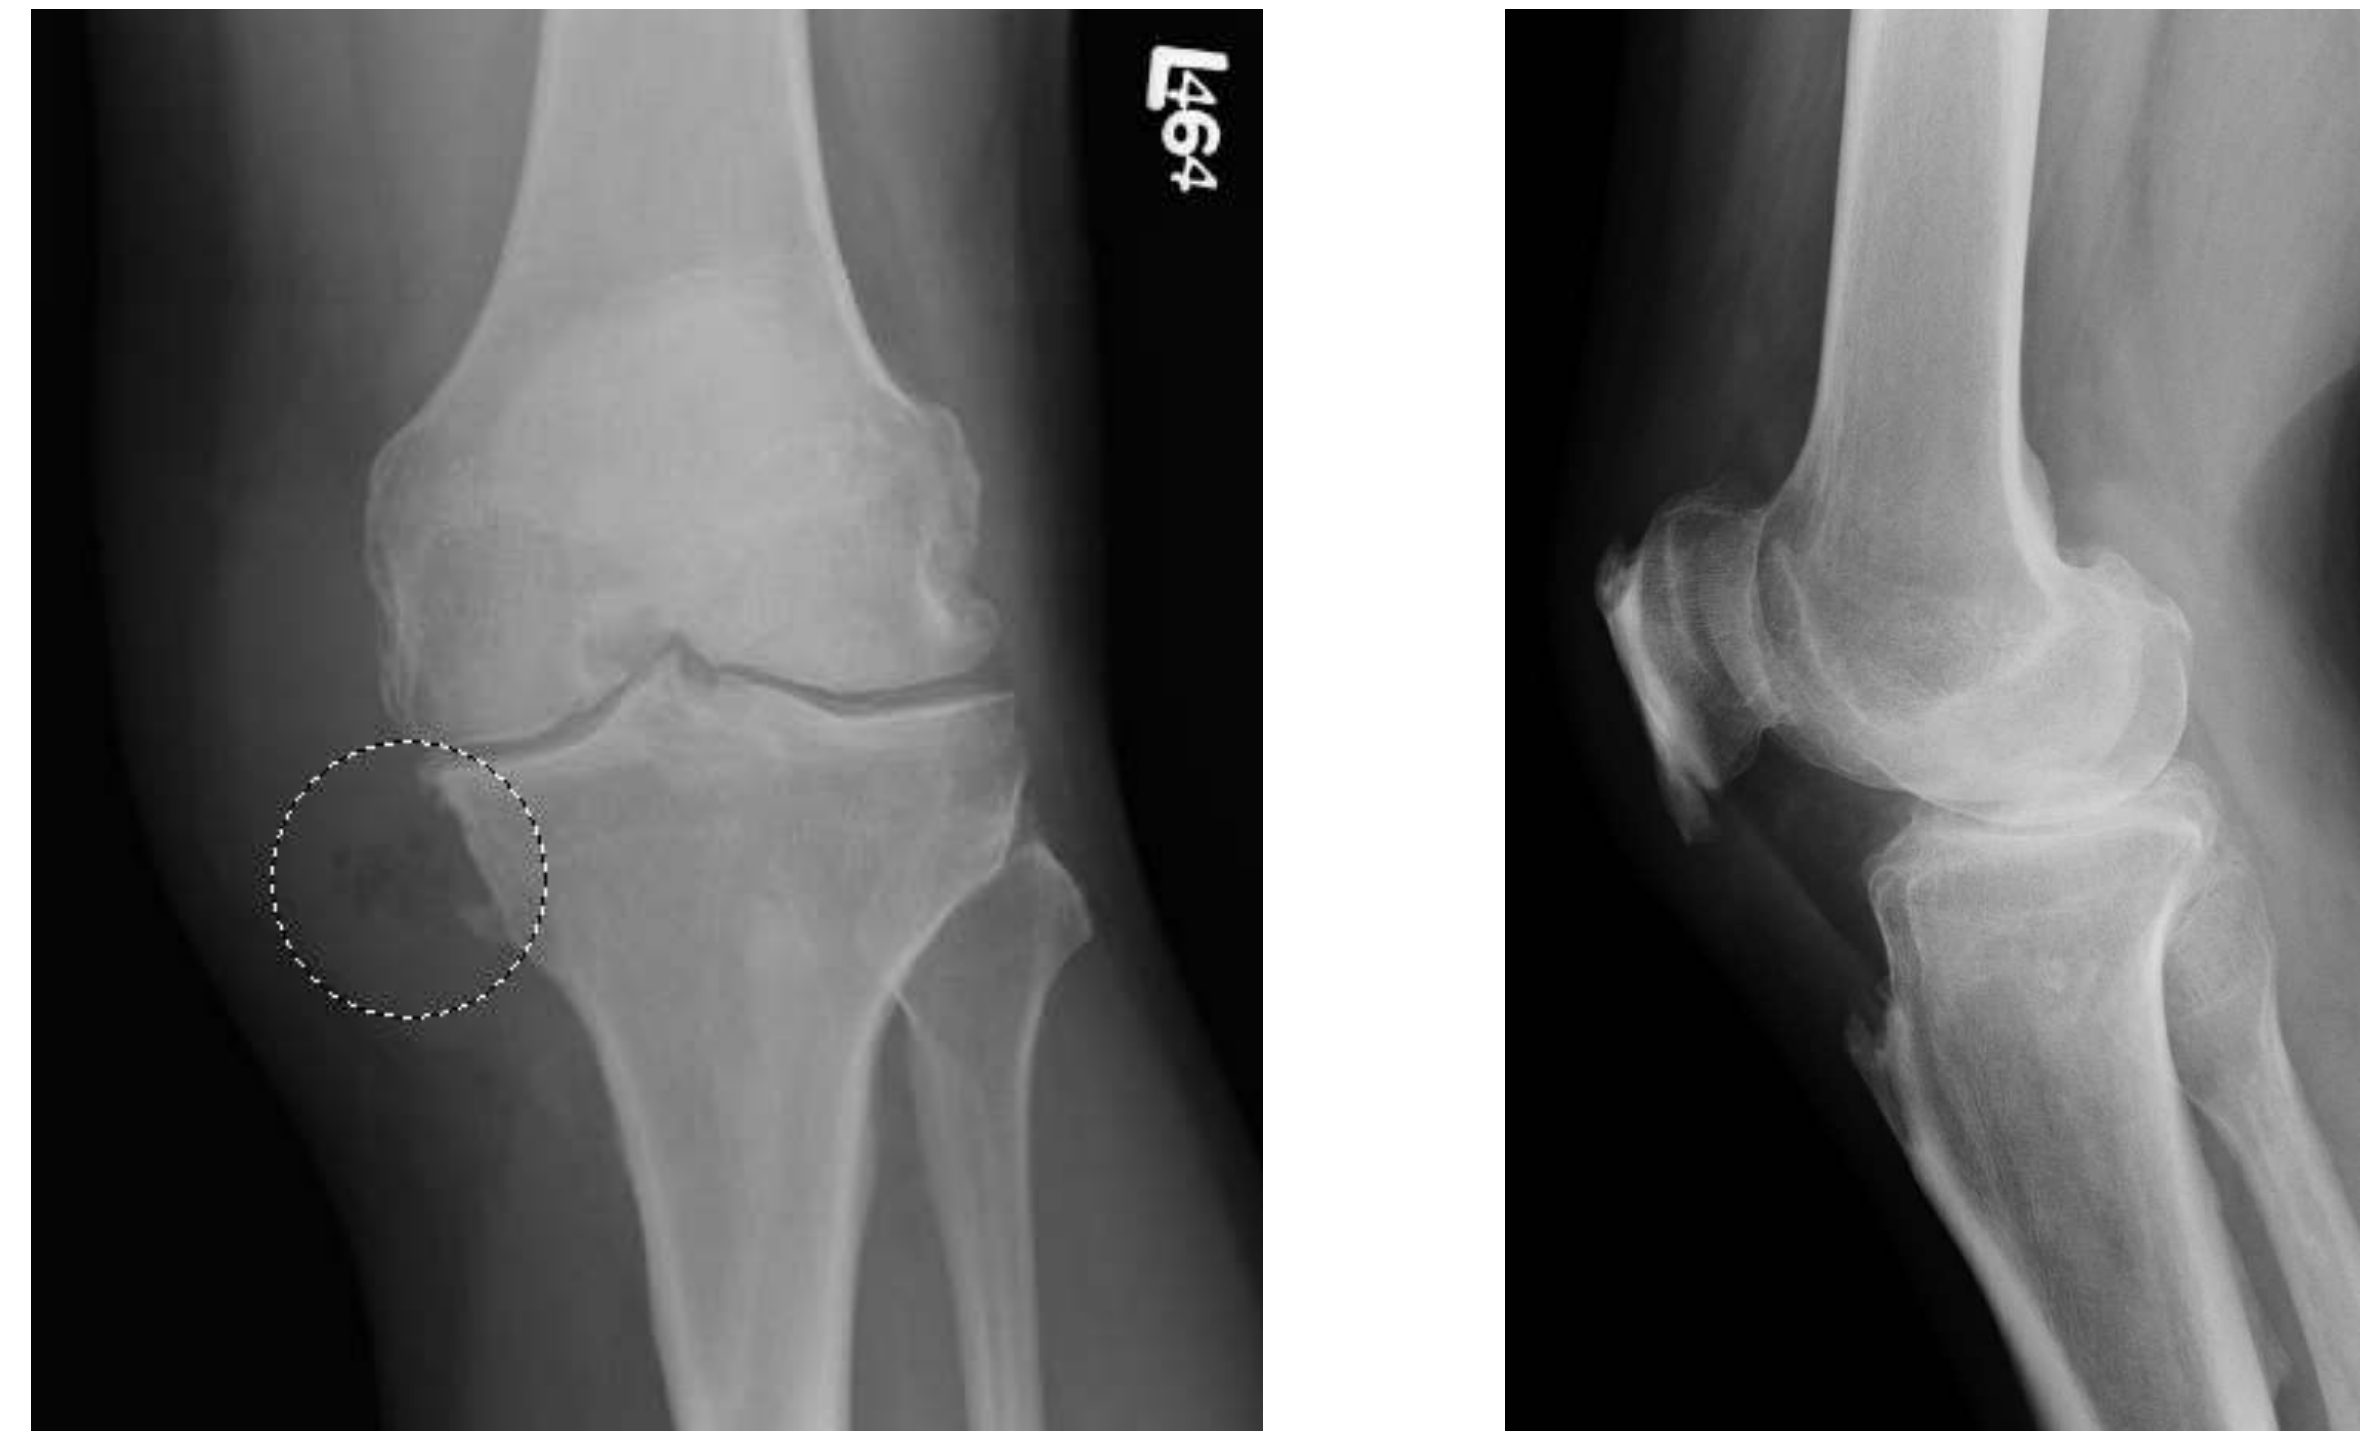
AP and lateral radiographs of the left knee. Several small bubbles of gas are seen in a round collection in the medial soft tissues is present (circle). Note the advanced degenerative changes in the knee joint.
